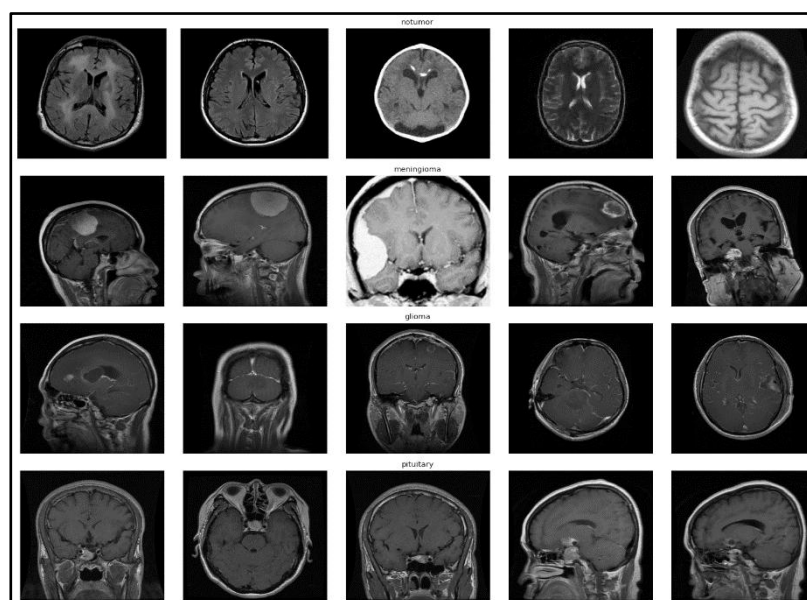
Representative Sample Images from the Brain MRI Dataset
